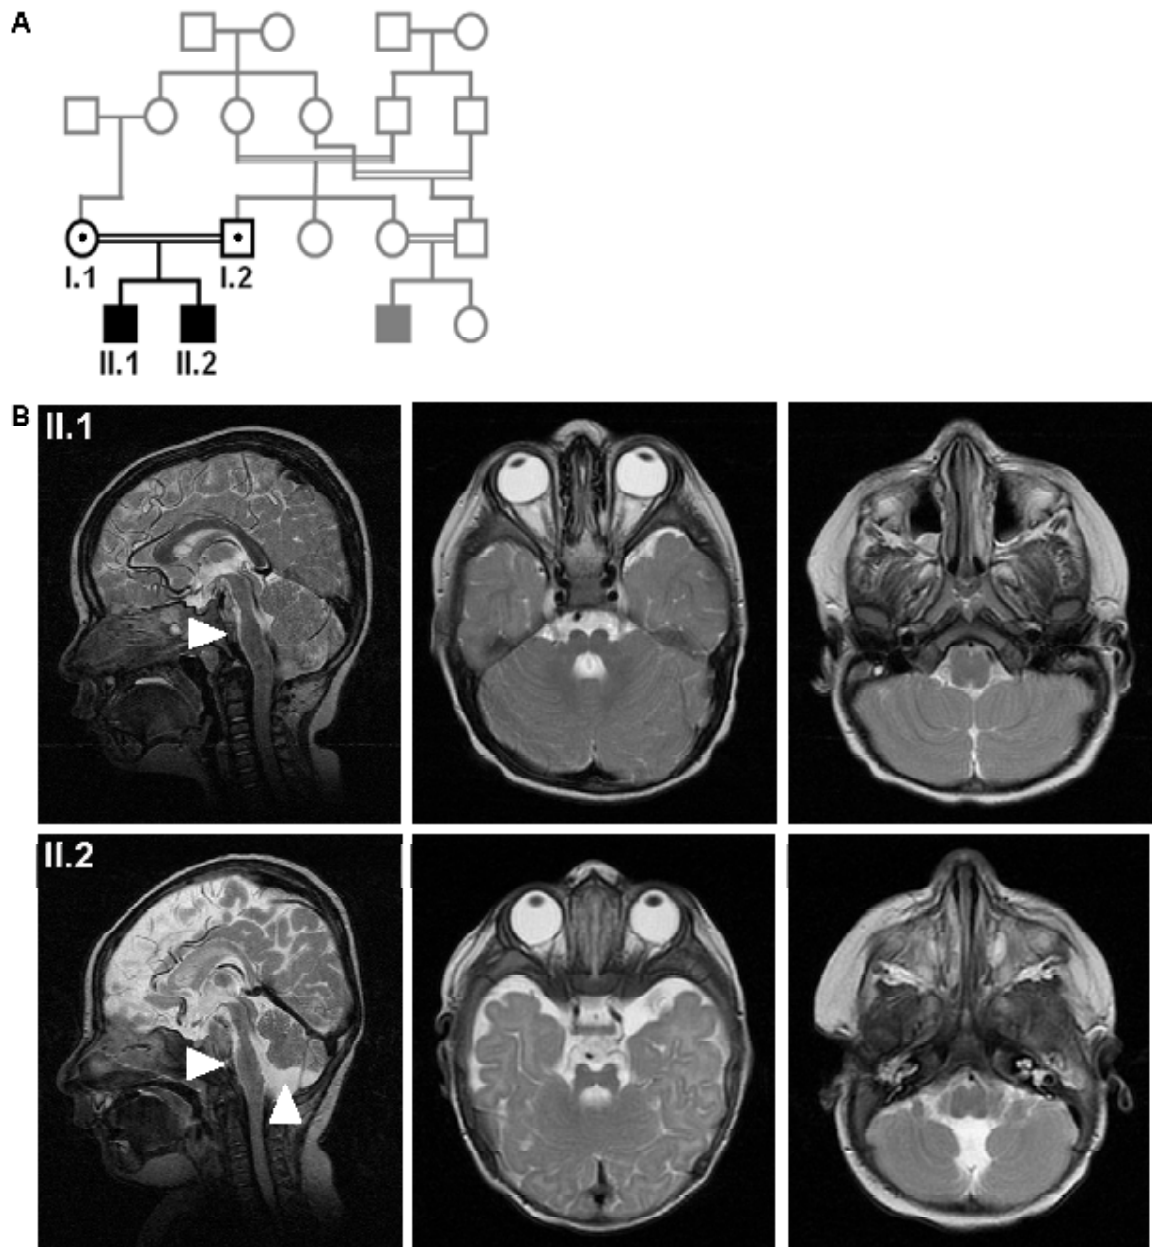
Phenotype of patients with midbrain-hindbrain malformation and intellectual disability. (A) The index patients are children (II.1, II.2) of healthy consanguineous Kurdish parents (first cousins) from Turkey. (B) Cranial MRI revealed microencephaly and hypoplasia of the pons and grooves (II.1, II.2) as well as hypoplasia of the cerebellum (II.2) or the caudal vermis (II.1). Arrow heads indicate hypoplastic pons (II.1, II.2) and cerebellum (II.2). Sagittal and axial T2 images.
